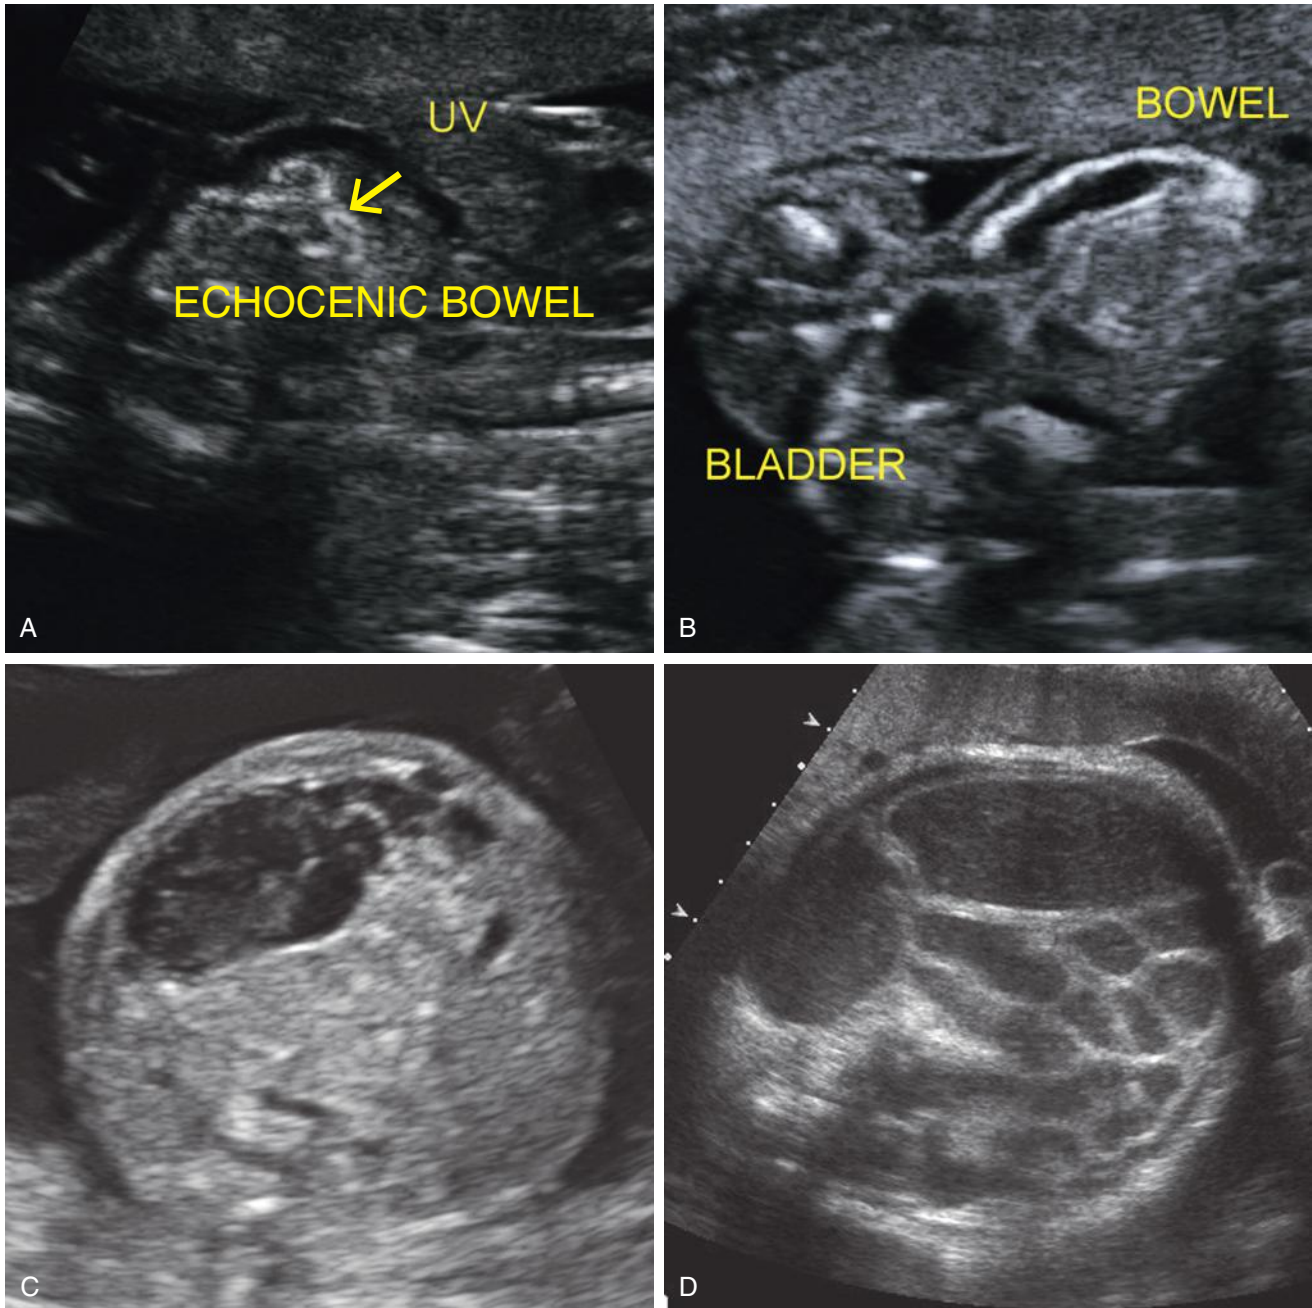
Evolution of jejunoileal obstruction. A, Typical sonographic appearance of echogenic fetal bowel (arrow) at 19 weeks. UV, umbilical vein. B, Of note on this follow-up examination, a slightly dilated loop of small bowel with an echogenic rim is shown. C, At 23 weeks, a heterogeneous intra-abdominal cystic structure with echogenic margins was noted, indicating a meconium pseudocyst. D, Progressive dilatation of fluid-filled small bowel segments was observed on serial obstetric sonograms. This is the appearance at 37 weeks. Immediately after birth, the child underwent resection of 27 cm of small bowel, with anastomosis of 104 cm of proximal to 52 cm of distal small bowel. She is now doing well without nutritional deficiencies. (D, Courtesy of Mary Frates, MD.)
